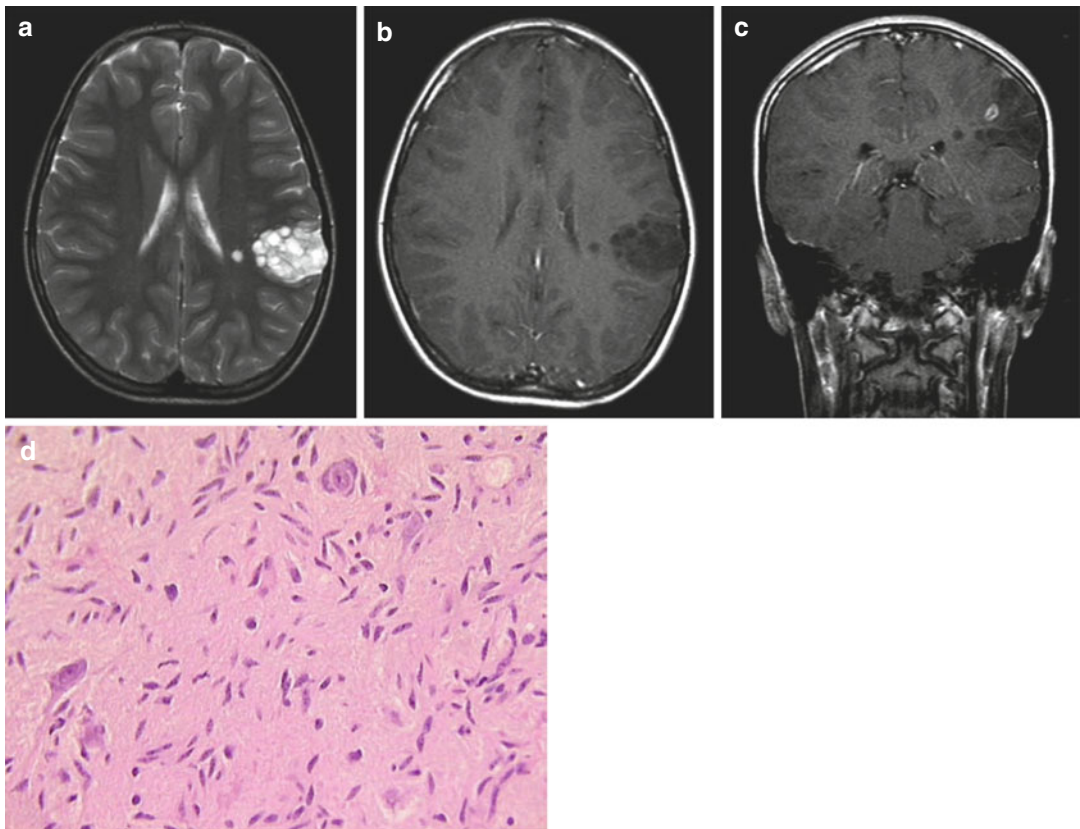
Dysembryoplastic neuroepithelial tumor (DNET). (a) T2-weighted axial MRI of a left parietal DNET demonstrates a typical “bubbly” appearance. The majority of the mass does not enhance following contrast (b), although a small focus of enhancement was noted
